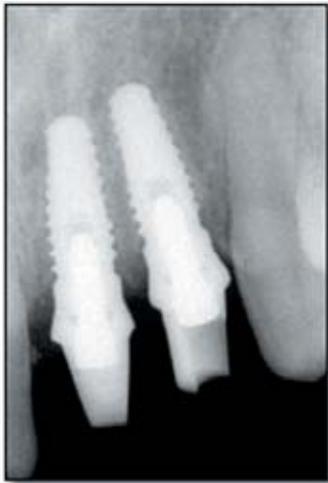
Periapical radiograph of posts in place.
